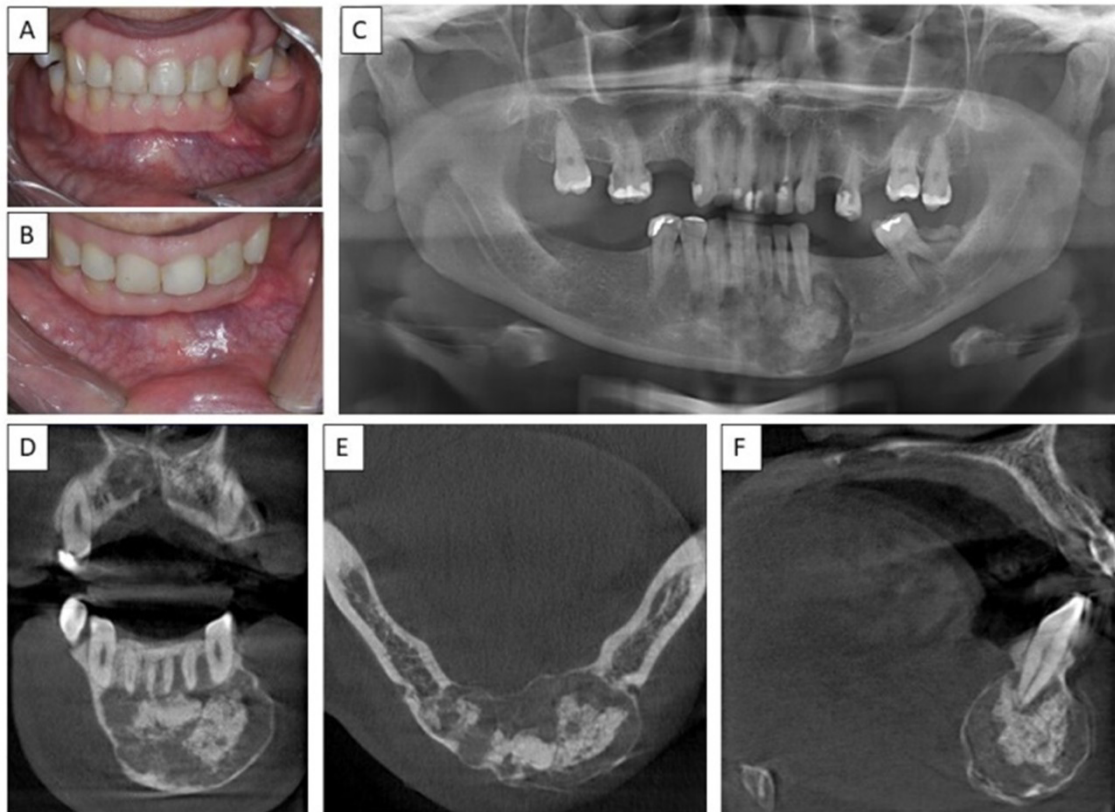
A and B) Intraoral aspect with mild bone expansion; C) Panoramic radiography showing mixed radiolucent image with radiopaque areas, sclerotic borders, extending into the anterior mandibular region, involving the periapex of teeth 33-44, expansion of the buccal and lingual cortical bone, without root resorption; D) Coronal section; E) Axial section; F) Sagittal section: well-defined hypodense image with hyperdense areas inside, showing expansion of the cortical bone without rupture.
